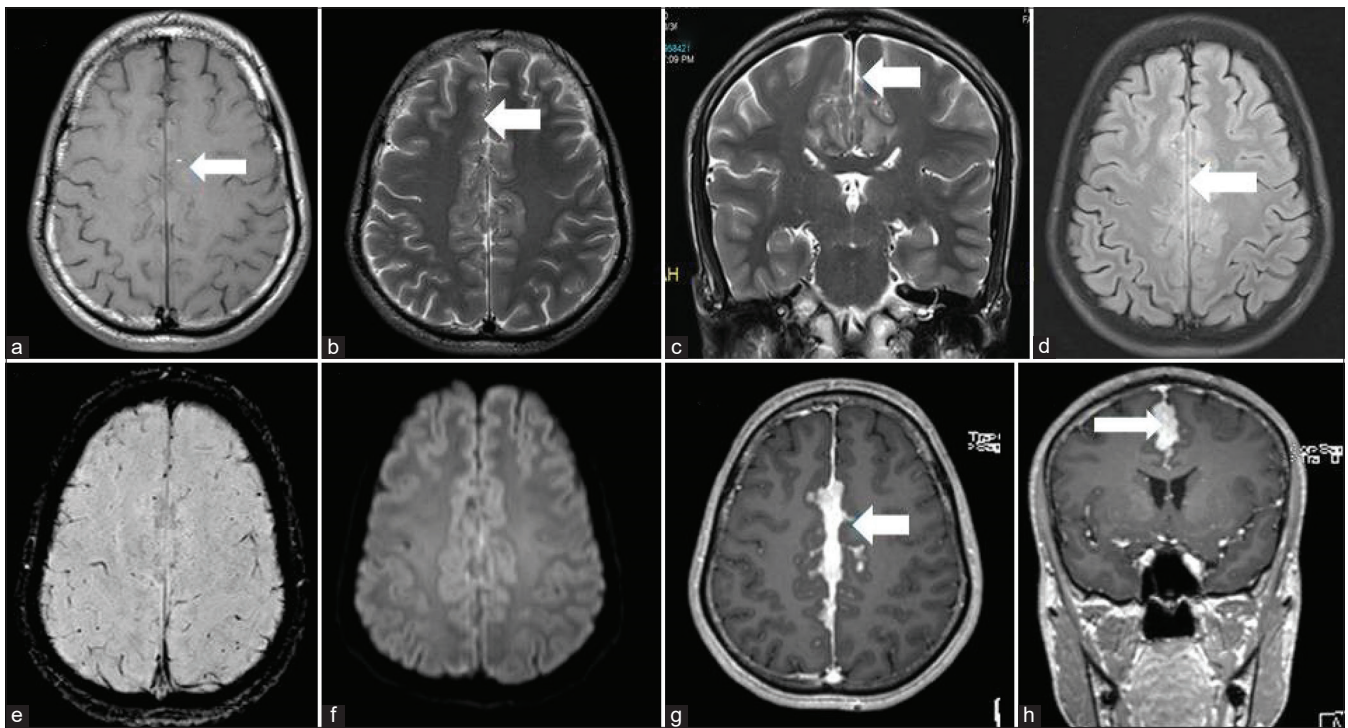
(a) Axial T1 image shows hyperintense lesions. (b and c) Axial and coronal T2-weighted images reveal nodular T2 hypointense ill-defined lesions in the interhemispheric location. Axial FLAIR image (d) shows mild perilesional edema in the cingulate regions. Susceptibility weighted imaging (e) shows no blooming. Diffusion-weighted trace image (f) demonstrates no evidence of restriction. The post-contrast T1-weighted axial and coronal (g and h) images show nodular and plaque like enhancement in the interhemispheric/falcine lesions with contiguous extension of the nodular enhancing foci into the sulci.
